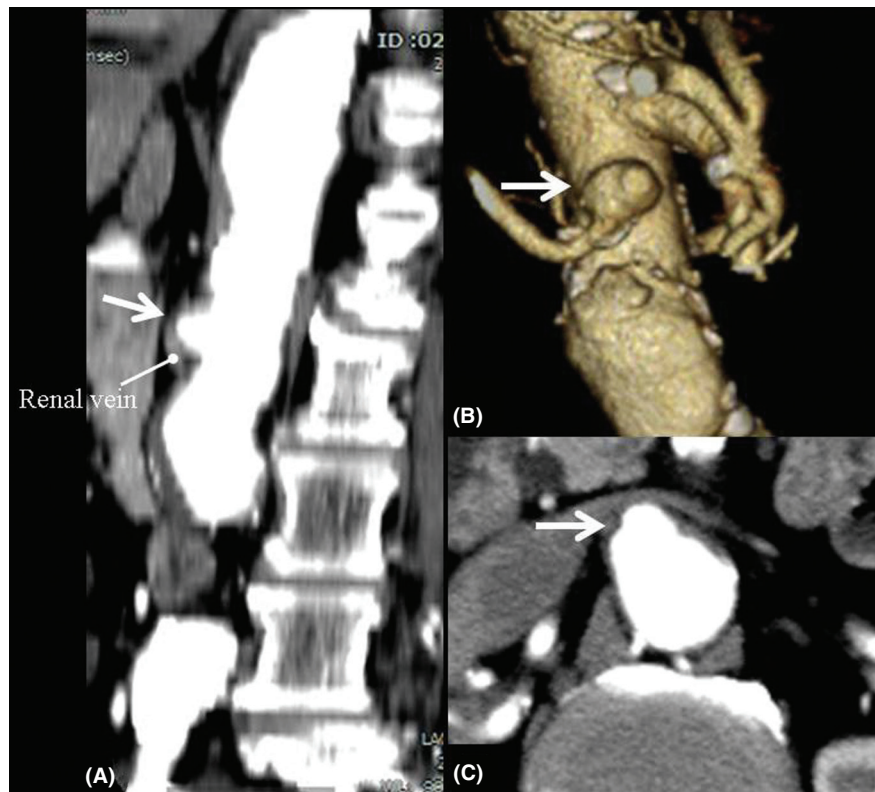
Preoperative computed tomograms. White arrow indicates the saccular pararenal aortic aneurysm involving the origin of the right renal artery. (A) Three-dimensional multi-planar reconstruction showing multiple aneurysms in the aorto-iliac segment. (B) Lateral view of the magnified image showing the saccular aneurysm involving right renal artery. (C) Axial tomography showing no protruding atheroma around the aneurysm and no severe thickening of the aortic wall.
